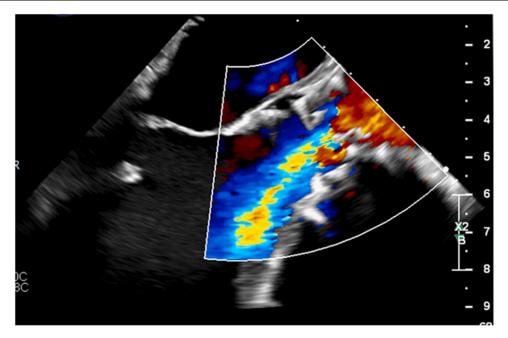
Transesophageal echocardiogram appreciating severe, continuous aortic insufficiency with a 34 mm Medtronic CoreValve Evolut transcatheter pericardial aortic valve prosthesis.
